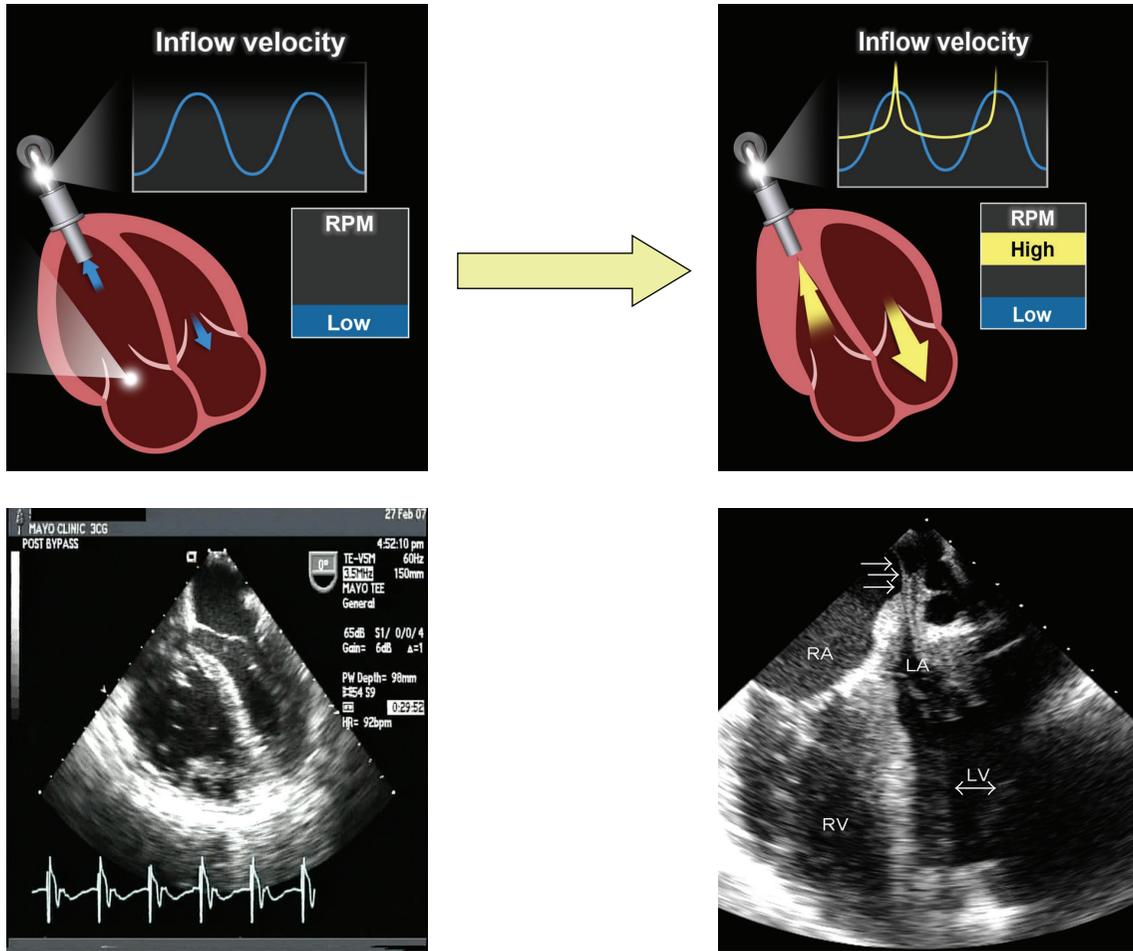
Inflow cannula obstruction, the “suction cascade”. Four-chamber transthoracic view representing the classic “suction cascade” that can manifest itself by a dilated hypocontractile RV, significant functional TR, small left ventricle, and intermittent inflow cannula obstruction by the collapsed LV.
